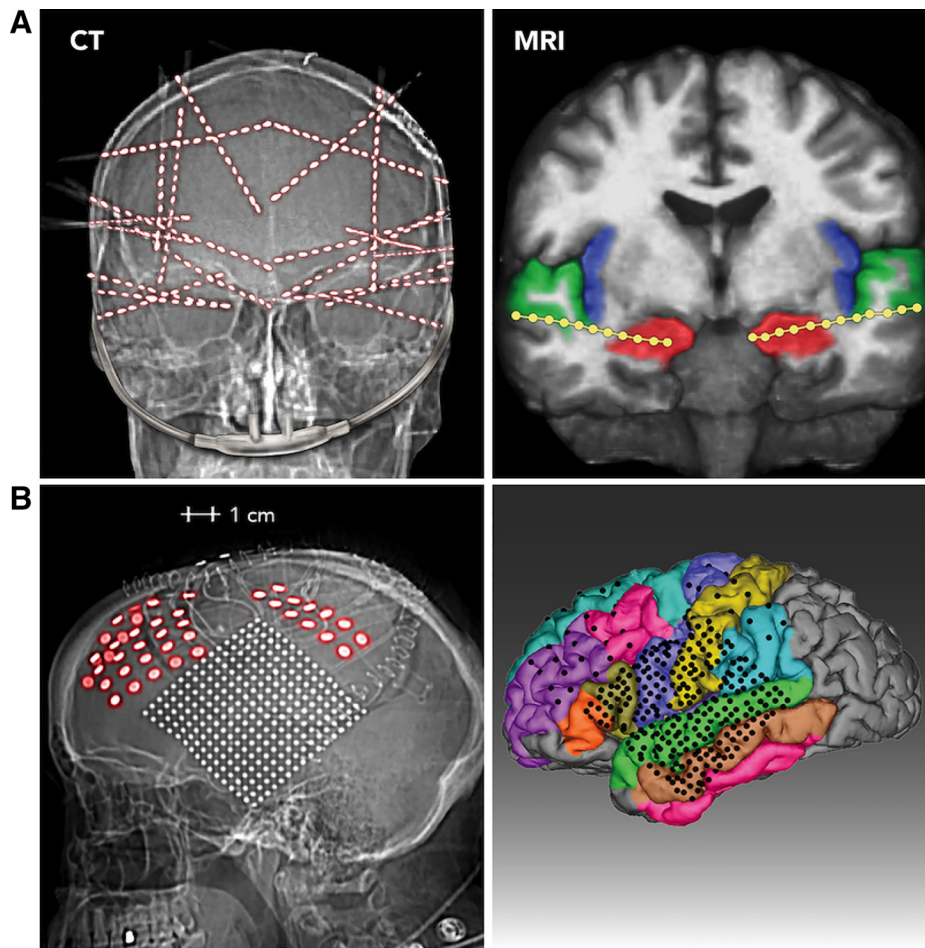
Electrode localization in 2 representative patients. Two methods of electrode survey are used. *A: CT (left)*. Postoperative skull radiograph is from 1 subject implanted with 20 stereo-depth EEG (sEEG) electrode arrays. Of the 320 contacts implanted in this subject, 231 were analyzed for breathing-related activity because they were outside the seizure onset zone and provided artifact-free signals. *Right*, MRI image of the same patient, showing 2 electrode arrays with the deepest contacts (1–4) in the hippocampi (red), superficial electrodes in the superior temporal gyrus (green), and a number of intervening electrodes lying in the white matter. *B: CT (left)*. Lateral view of head radiograph is from the 1 subject who was implanted with subdural ECoG grids and strips. *Right*, MRI reconstruction showing the location of the electrodes on a parcellated brain (FreeSurfer; Dale et al. 1999; Fischl et al. 1999).
